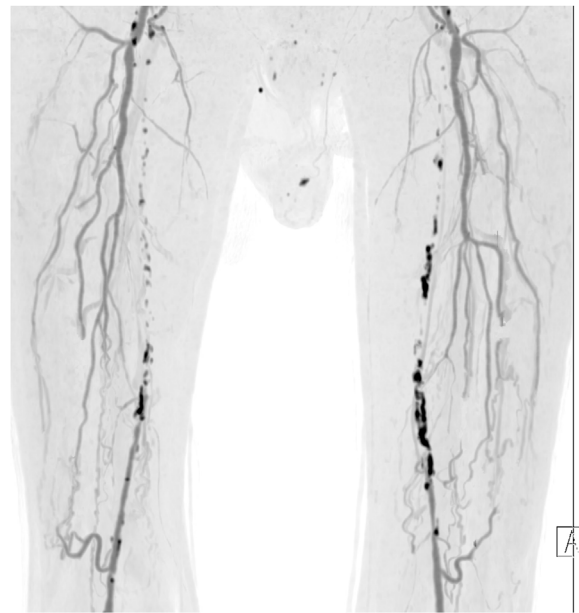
Preoperative CT maximum intensity projection showing atherosclerotic occlusion of the bilateral femoro-popliteal segments.
